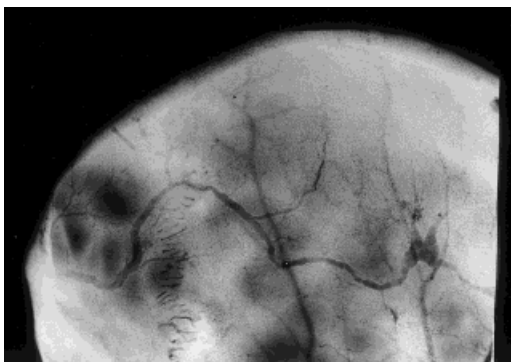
Oblique x-ray view of diploic vein pattern. Continuation of the serpentine vein with occipital diploic vein (notice lambdoid suture to the left).
